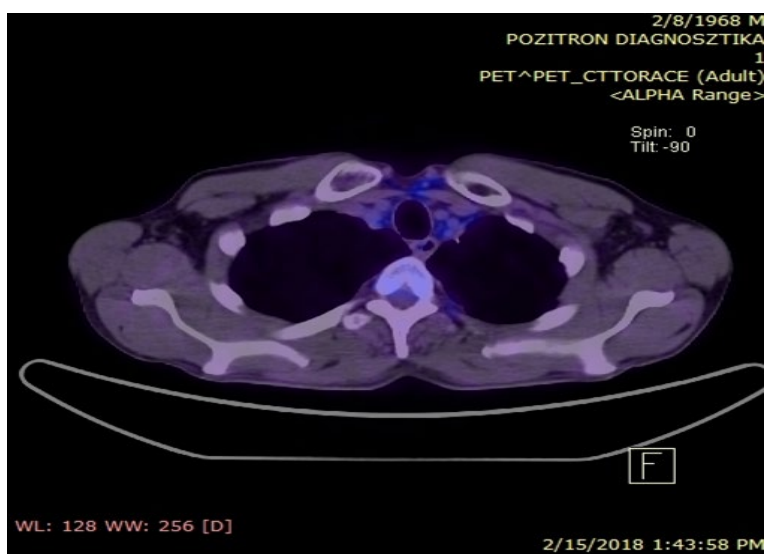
PET-CT (15.02.2018): Complete Response
